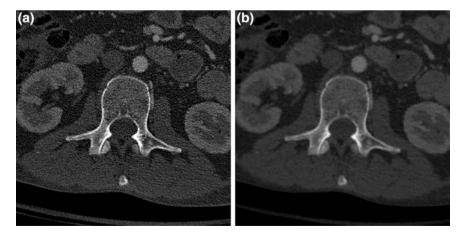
CT images of the spine demonstrating different reconstruction kernels. Axial plane images from a CT study of the spine, performed with \mathbf{a} "bone" reconstruction kernel for the body (B70), and \mathbf{b} "soft tissue" reconstruction kernel (B40). Note difference in edge definition and noise between images
